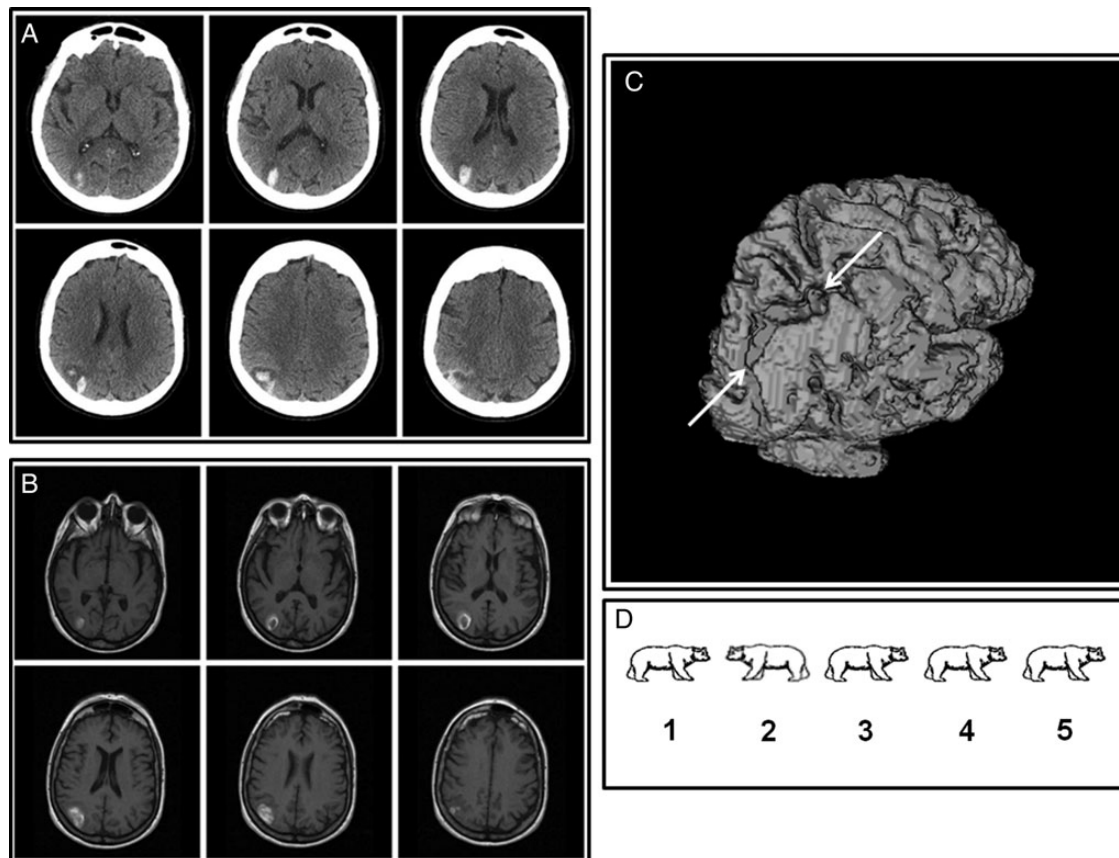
Brain imaging of the patient. (A) Axial cerebral CT-scan at the acute stage showing spontaneous occipitoparietal hyperdensity. (B) T1 axial cerebral MRI at the chronic stage showing occipitoparietal high-signal intensity. (C) 3D reconstruction; white arrows show the beginning and the end of the lesion (light gray). (D) Example of stimuli for the mirror and orientation agnosia test in 'mirror' condition.
